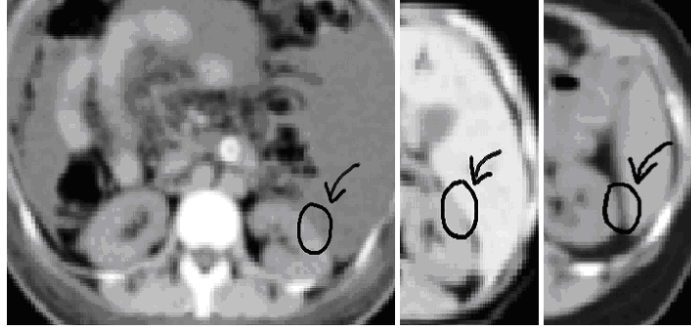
Corresponding axial slices of three CT images of the abdomen. An anatomically corresponding region may show a different intensity pattern across images. Here the kidney-liver interface is highlighted and shows all three profiles types discussed above. (Rao et al., 2005)
